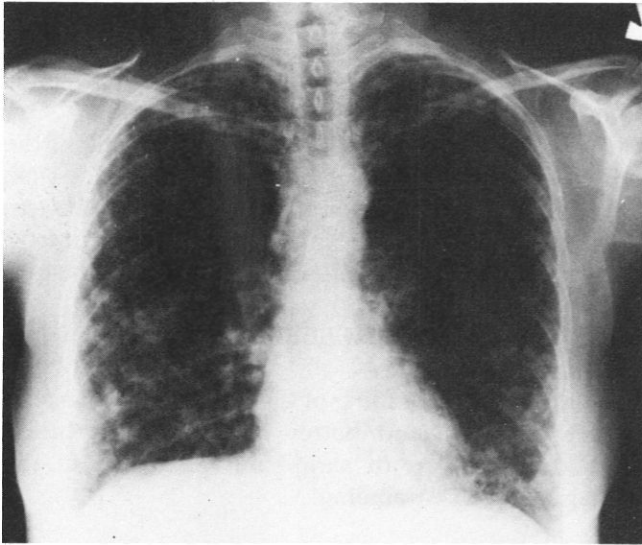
Postero-anterior radiograph of the chest shows widespread pulmonary nodules.
